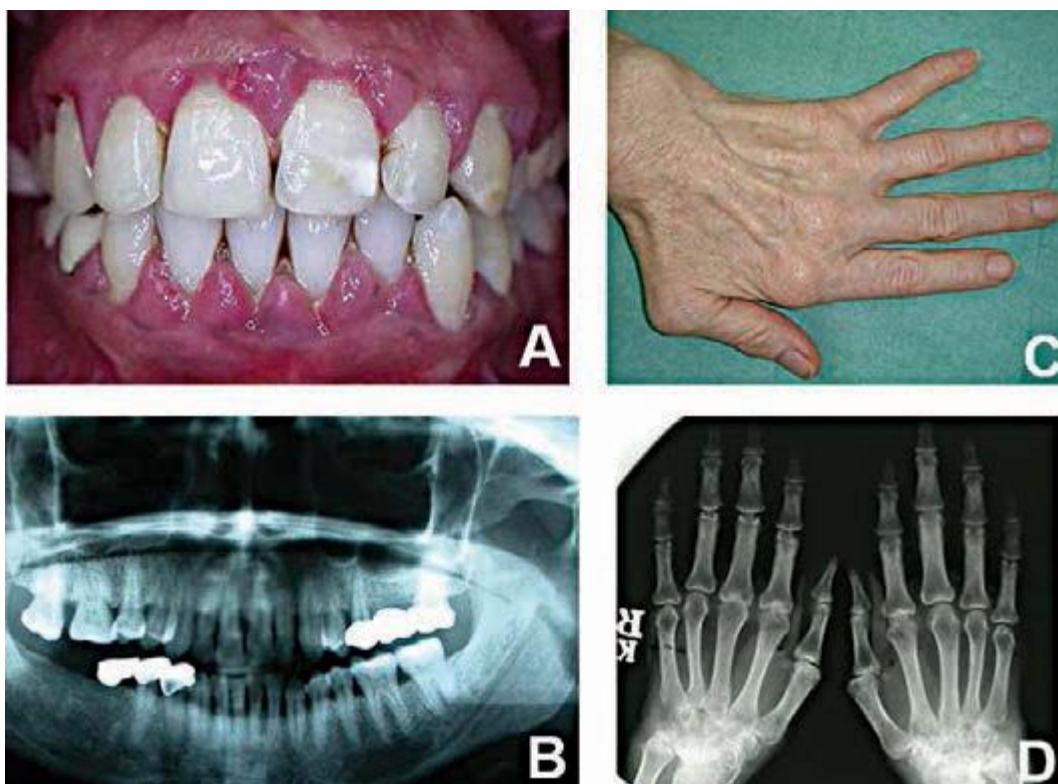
Clinical and Radiographic Presentation of PD (A, B) and RA (C, D)
